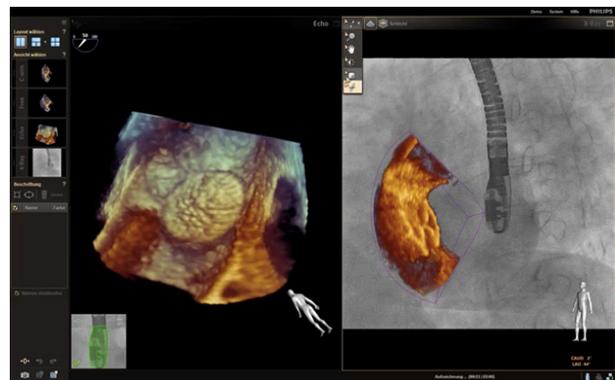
Real-time fusion of echocardiographic and angiographic images facilitate the procedure. On the left a PFO-Occluder is shown from the right atrium. On the right the 3-D-Echo-image is fused with the fluoroscopy in a 45°LAO projection.
